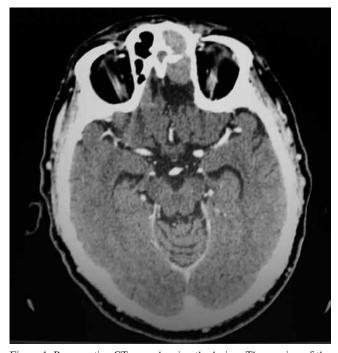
Preoperative CT scan showing the lesion. The erosion of the posterior wall of the left frontal sinus is visible.
